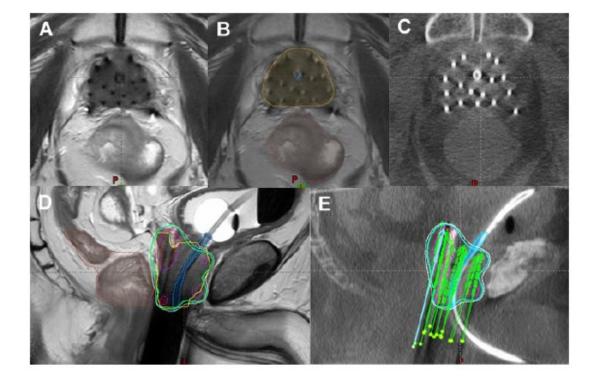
Mid-gland axial and sagittal views of a patient with a prostate HDR implant on (A) & (D) MRI and (C) & (E) intraoperative CBCT, respectively. The registration of the two datasets, with a 50% MRI-CT blending in the axial view is depicted in (B). The MRI dataset (axial and sagittal T2 sequences obtained with the patient under general anesthesia, using a 3.0T Philips Ingenia MRI scanner) is used for target delineation, while the CT is typically used for applicator reconstruction.
